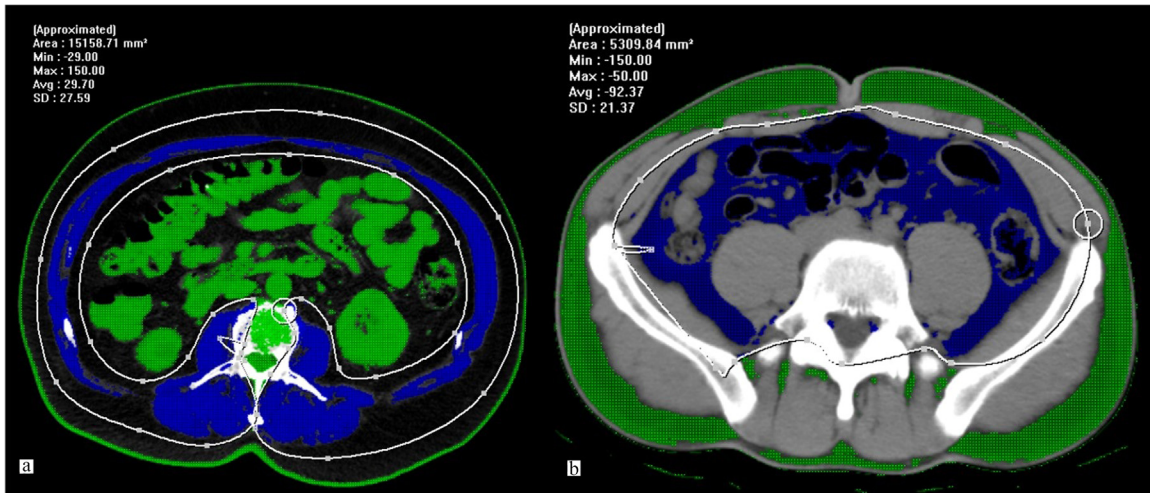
Abdominal CT images taken at the third lumbar vertebra applied to quantify (a) total skeletal muscle area. Skeletal muscle area included the psoas, the erector spinae, the multifidus, the quadratus lumborum, and abdominal wall muscles. The skeletal muscle was identified and areas were quantified using CT viewer tissue segmentation program. A threshold range of -29 to 150 HU was used to define skeletal muscle. Total muscle area is colored in blue (b) Abdominal CT images taken at the level of the umbilicus applied to quantify visceral adipose tissue area. A threshold range of -150 to -50 HU was used to define visceral adipose tissue which is colored in blue. (Color version of figure is available online.)
